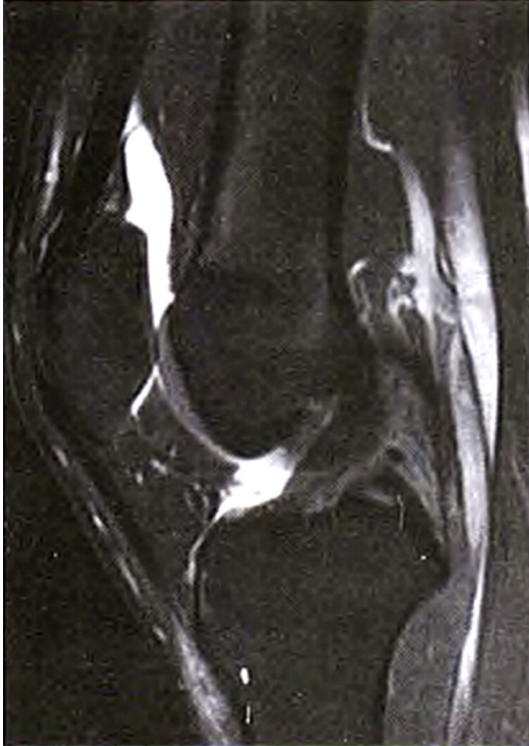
MRI showed anterior cruciate ligament rupture.
